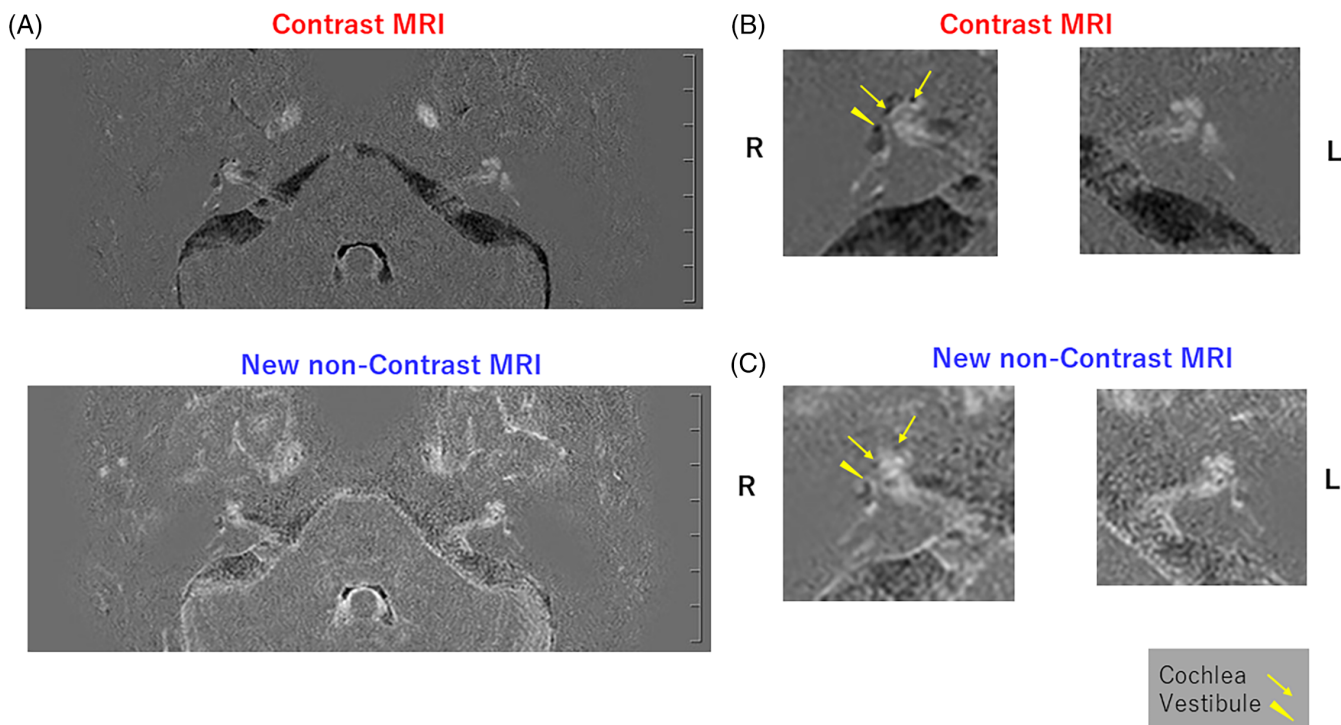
Images comparing contrast and new non-contrast MRI of Patient 3. Patient 3 was a 34-year-old woman with Stage 3 right-sided Ménière's disease. (A) Images of the inner ear at the cerebellopontine angle: The upper row is contrast MRI and the lower row is new non-contrast MRI. (B) Magnified images of the inner ears by contrast MRI. (C) Magnified images of the inner ears by new non-contrast MRI. Lesions with decreased signal intensity are apparent in the new non-contrast MRI; they are consistent with images considered to represent endolymphatic hydrops in the left vestibule and cochlea.
